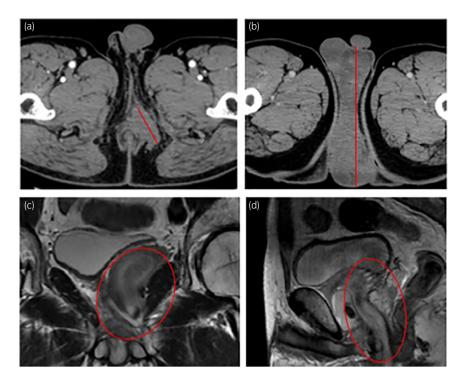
(a) Enhanced computed tomography (CT) showed a 7 cm mass lesion in perineal zone 3 years before. The red bars indicate the length of the mass. (b) Enhanced CT shows a 16 cm mass lesion without enhancement. (c) Sagittal and (d) Coronal MRI showed a high intensity lesion with swirled appearance on the T2-weighted images. The red circle indicates the "swirling and layering pattern".
